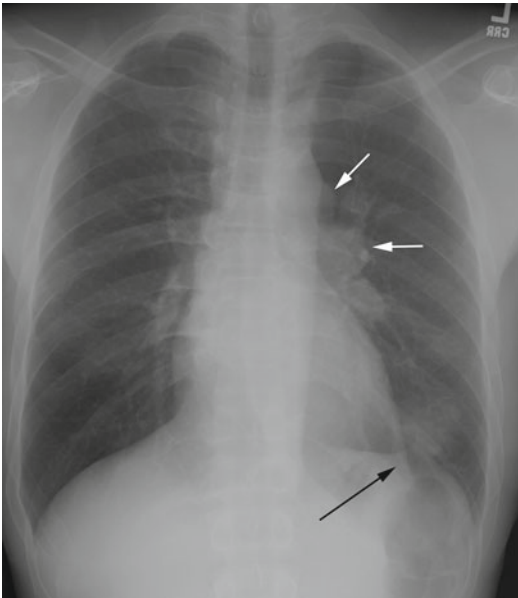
Frontal chest radiograph reveals left lower lobe poorly defined nodule (*black arrow*) with associated left hilar and aortopulmonary window adenopathy (*white arrows*)
